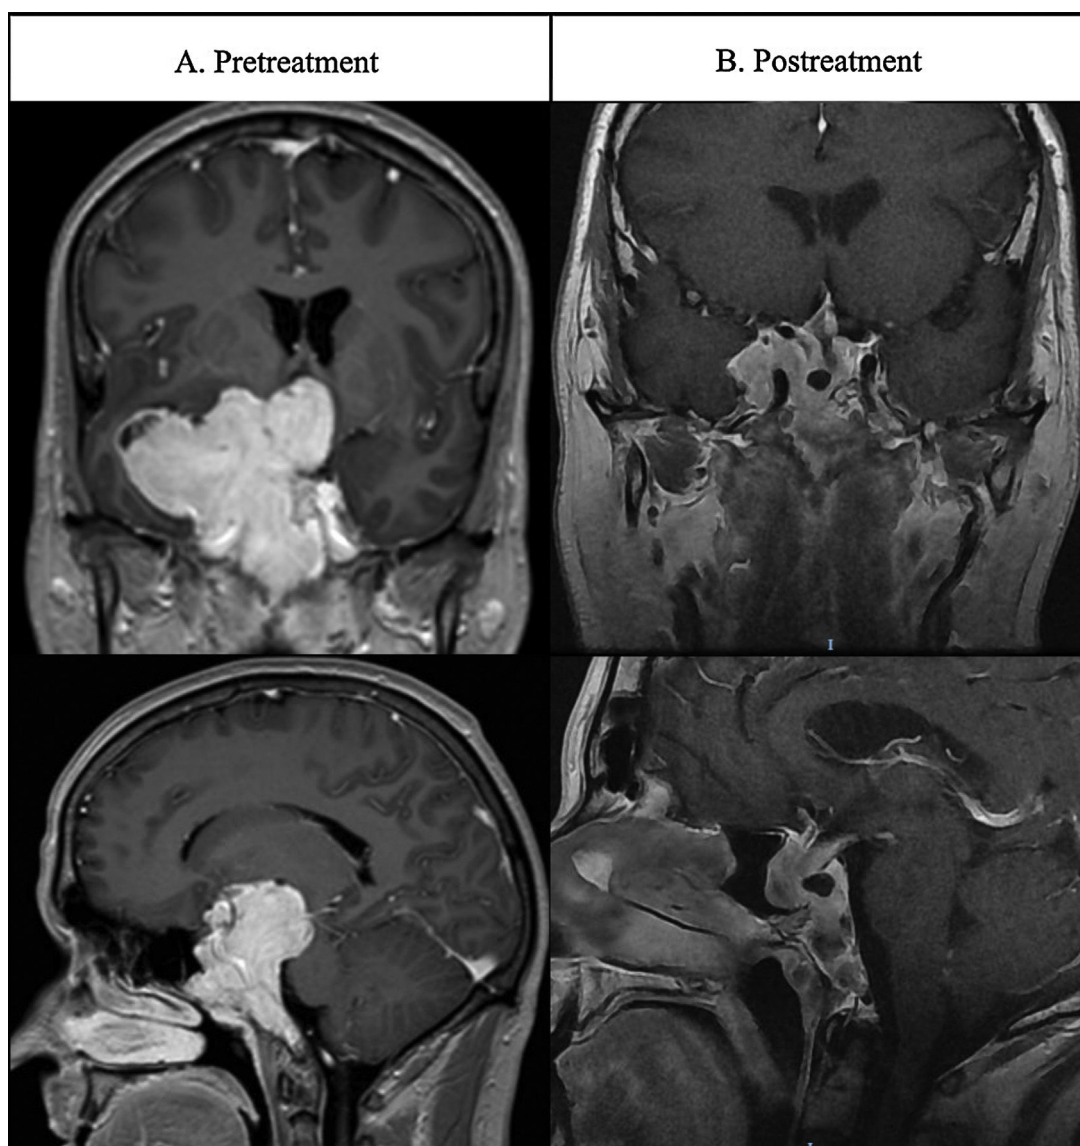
Patient 1's MRI images at presentation and after medical treatment.
